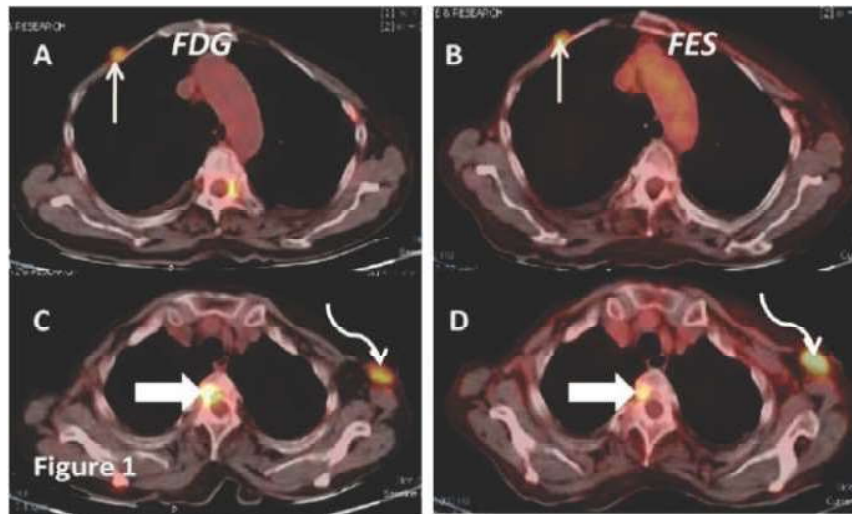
FDG- PET CT showing multiple lesions (as shown by arrows) in thorax.
